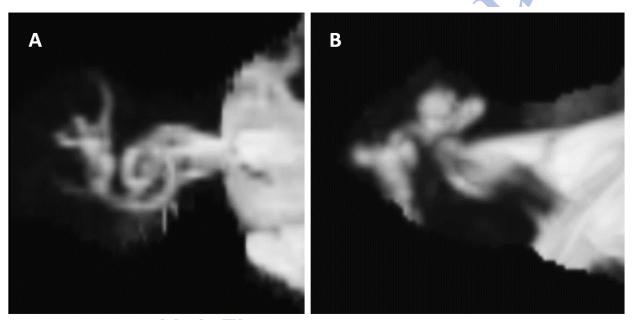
T2-weighted 3-dimensional magnetic resonance tomography reconstruction of right ear labyrinth from anterior (A) and inferior (B) views.
